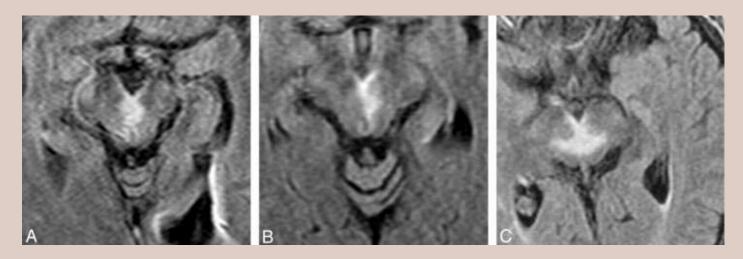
2 Axial FLAIR MR images through the midbrain A,B,C depicts a V-shaped hyperintense signal, intensity along the pial surface of the midbrain at the interpeduncular fossa (the V sign).
